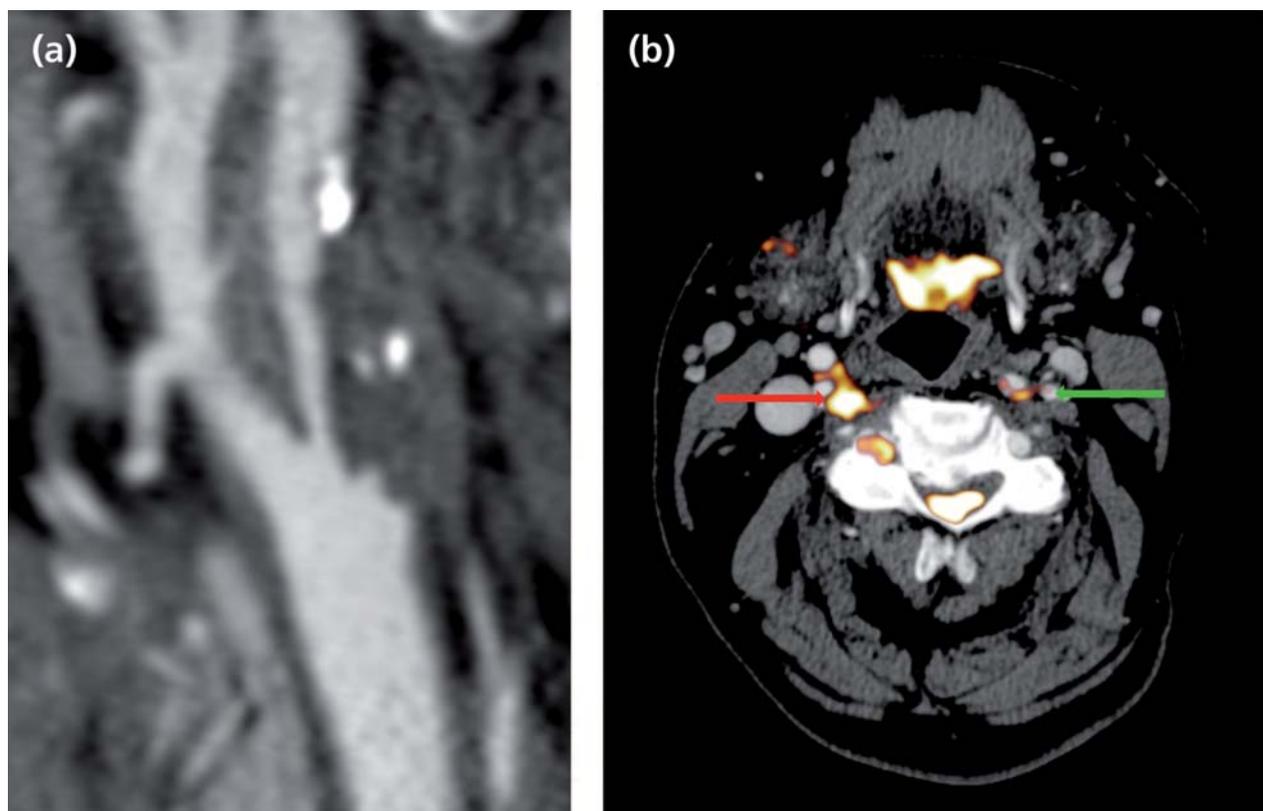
FDG-PET/CT imaging in symptomatic carotid atherosclerosis. (a) CT angiography: three-dimensional multiplanar reformatted image of a severely stenosed right internal carotid artery 1 week after an acute cerebrovascular event in a 69-year-old man. (b) FDG-PET: transaxial image of PET co-registered to CT angiography in the same patient. Intense tracer uptake is noted in the culprit right internal carotid artery (red arrow). Lesser uptake is noted in the left internal carotid artery (green arrow). CT, computed tomography; FDG, [18 F]-2-fluoro-2-deoxyglucose; PET, positron emission tomography.
